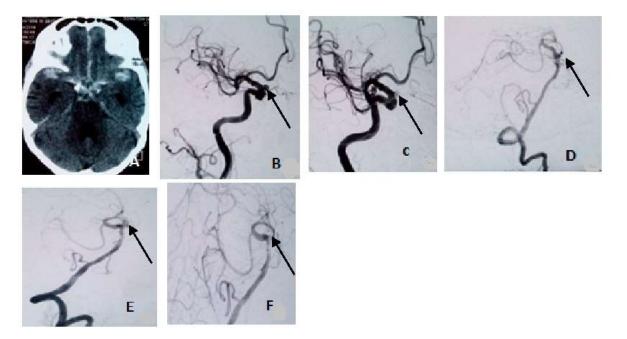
A CT scan at present admission revealed subarachnoid hemorrhage in basal cistern, perimesencephalic cistern and Sylvian fissure. B wide neck aneurysm right ophthalmic origin toward anterior measuring 5x6 mm irregular shape, C post stent assisted coiling, D unruptured aneurysm measuring 6x3mm above the vertebrobasilar junction with the tip directed left side and superiorly. E ruptured aneurysm after taking antiplatelets, F post coiling.
